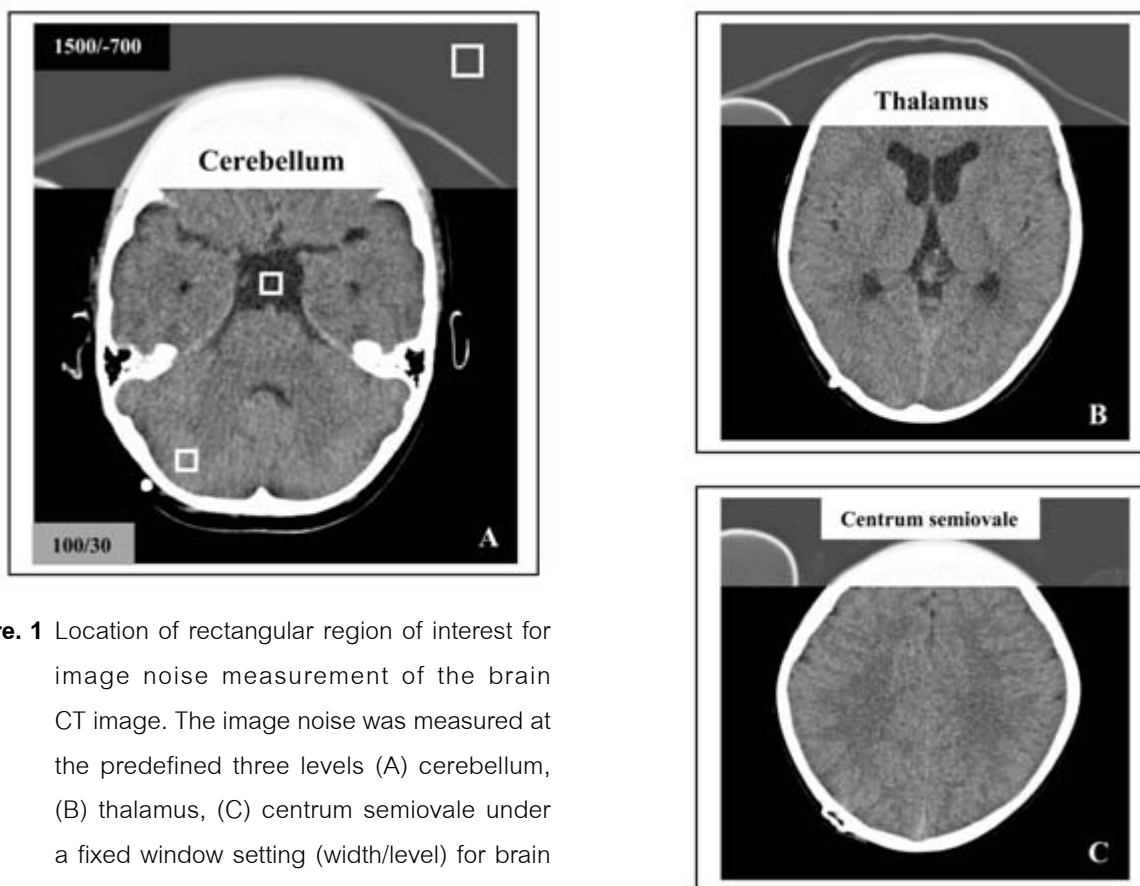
Location of rectangular region of interest for image noise measurement of the brain CT image. The image noise was measured at the predefined three levels (A) cerebellum, (B) thalamus, (C) centrum semiovale under a fixed window setting (width/level) for brain (100/30) and background air (1500/-700).
